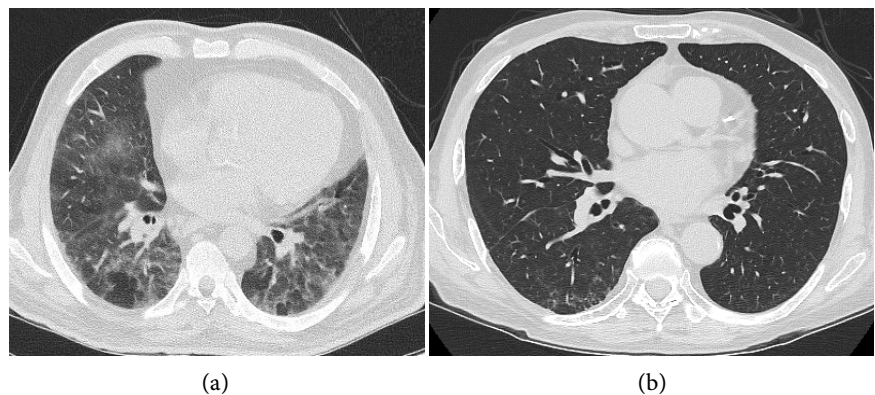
Axial CT view showing significant bilateral, mosaic, ground glass opacities in the middle lung zones prior to Rituximab therapy (a) and improvement with just residual fine reticulation on the right posterior segments after therapy (b).
